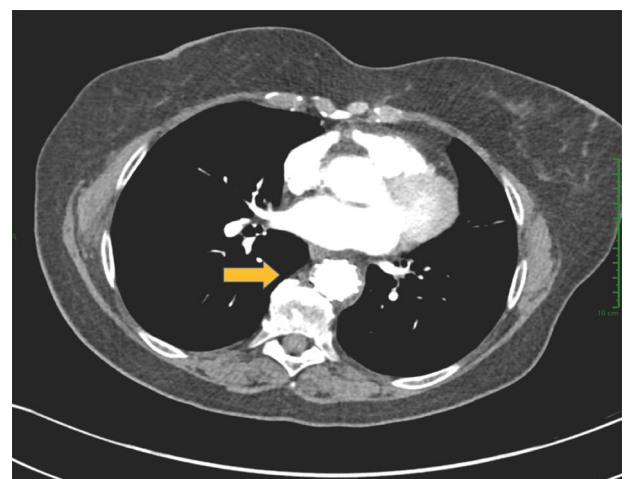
CT angiography scan, with no signs of infection. Stent graft is in place with no evidence of endo-leaks. CT indicates computed tomography.
